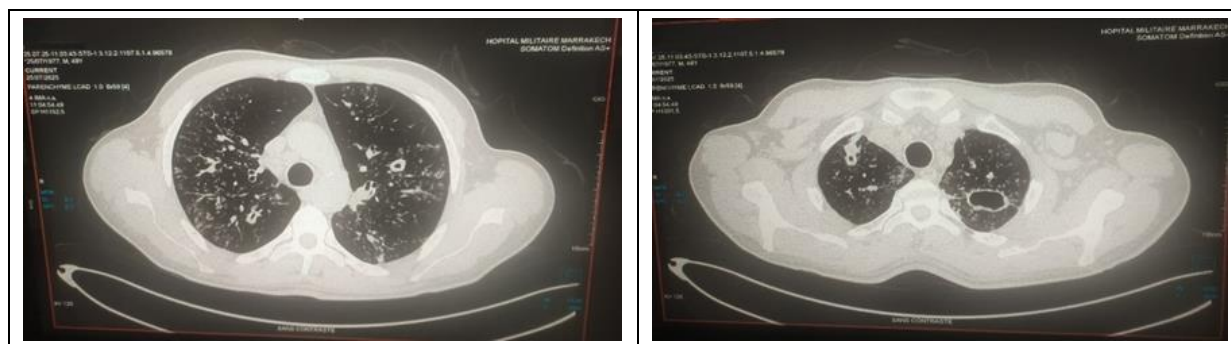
Chest CT demonstrating post-primary pulmonary tuberculosis with active lesions
